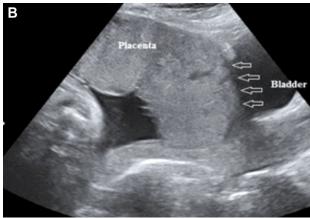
2D/3D and power Doppler US images showing the US criteria for PA diagnosis: (A) Thinning of the uterine serosa-bladder interface (arrows); (B) Loss of the retroplacental clear space (absence of the myometrium – arrows). 2D: Two-dimensional; 3D: Three-dimensional; PA: Placenta accreta; US: Ultrasound.
